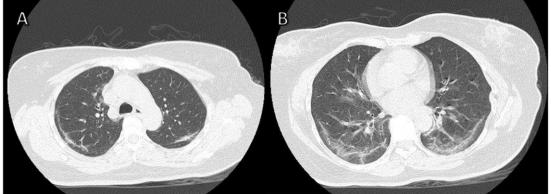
Axial section, lung window, chest CT scan after COVID-19 patient, 47 years old female patient showed fibrosis
